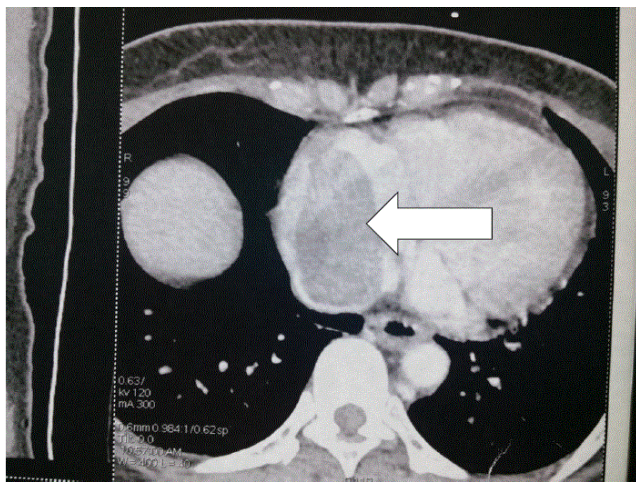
CT showing a mass in the right atrium.
